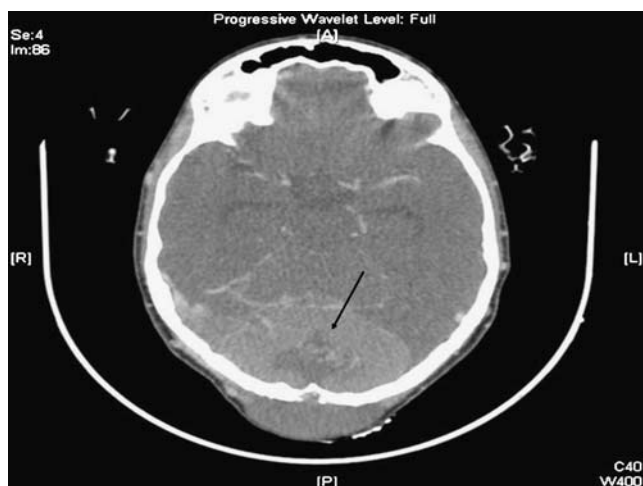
Computed tomography (CT) of head revealing a vascular soft tissue mass (arrow) measuring $8.4 \times 7.4 \times 6$ cm in the occipital region, showing bone destruction
